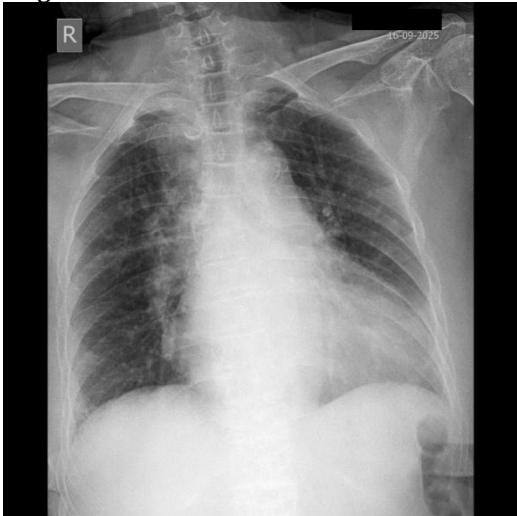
Chest X-ray showing early pulmonary edema, bronchopneumonia, cardiomegaly, left ventricular hypertrophy (LVH), and aortic sclerosis.
